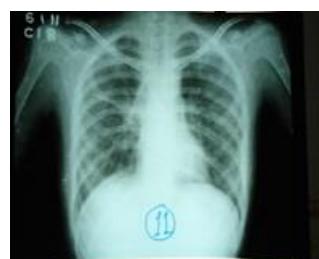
X-ray chest revealed no abnormality.
